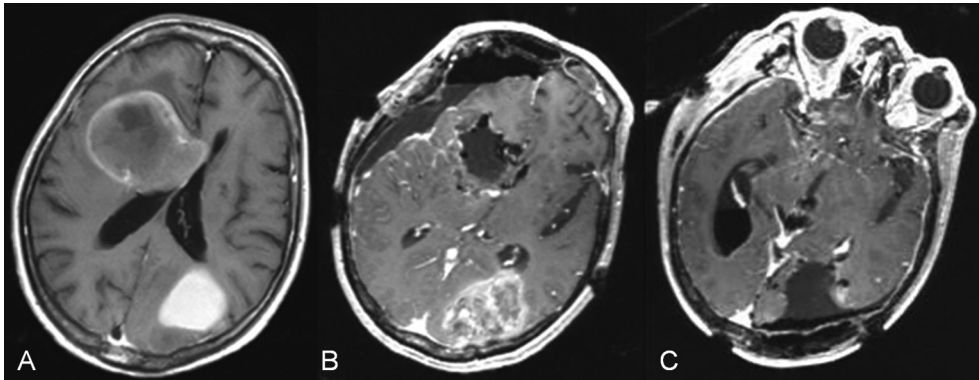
Magnetic resonance T1-weighted images with gadolinium show right frontal and left occipital lesions (A). Removal of right frontal tumor was confirmed by intraoperative magnetic resonance T1-weighted images with gadolinium after first surgery (B). Removal of left occipital tumor was confirmed by intraoperative magnetic resonance images after second surgery (C).
